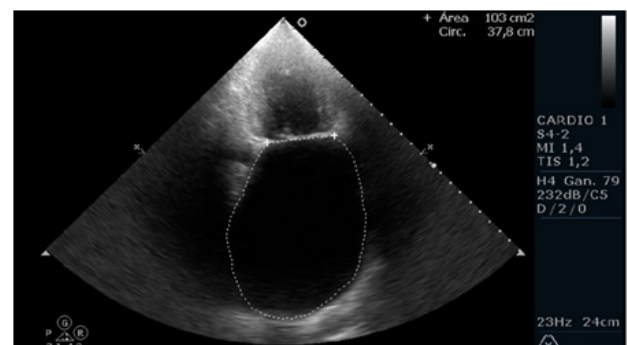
Apical echocardiographic view of two cameras with left atrial area measurement widely increased (103 cm²) and inferosuperior distance of 12.6 cm. Obtaining a volume of left atrium by biplanar method of 778 ml
